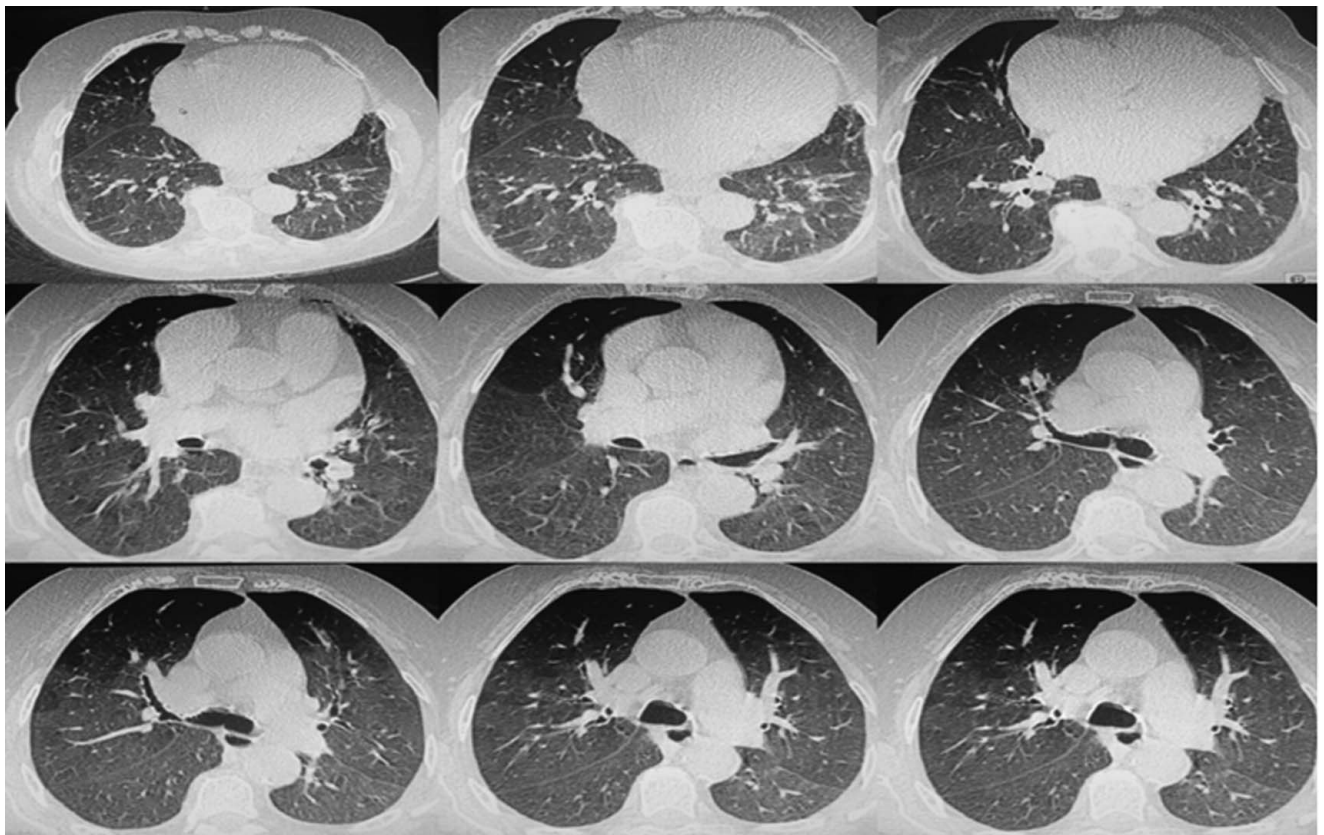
Computed tomography scan findings.
